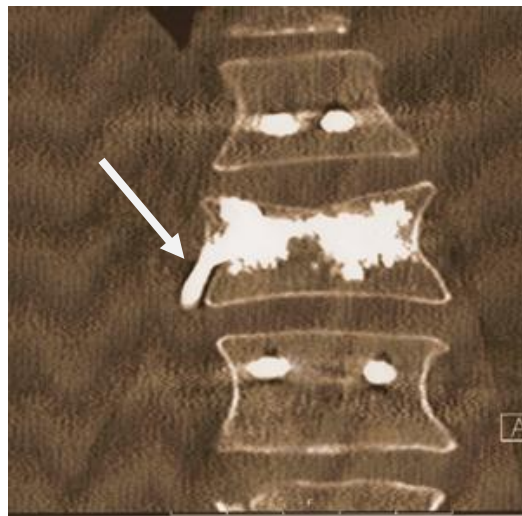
Case 2. Coronal reconstructed CT scan showing lateral extraspinal cement extravasation (white arrow) through the fracture line of the involved vertebra.
